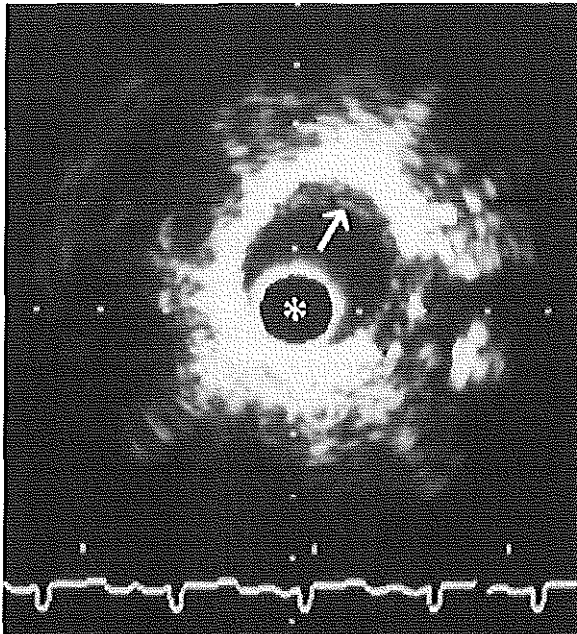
Intravascular ultrasound image of a peripheral pulmonary artery of patient 11. *: ultrasound catheter. Note the gray layer at the inner border of the vessel wall (arrow). Distance between two white points is 1 mm.
